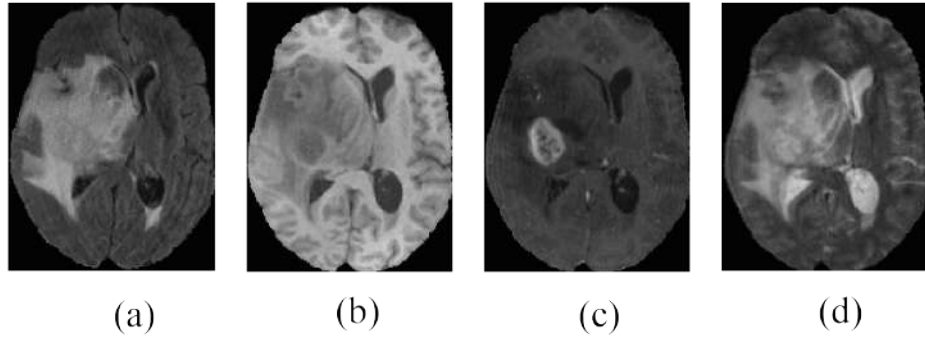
Different Multimodal MRI Scans (a) FLAIR (b) T1 (c) T1CE (d) T2 [1]
